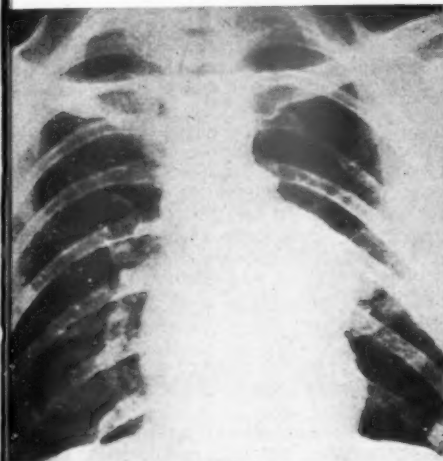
P.A. chest radiograph 20.12.55 showing prominent left subclavian artery and aneurysm distal to coarctation site. Rib notching is best seen in the right 8th rib, and the left 5th rib has regenerated following the first thoracotomy.
